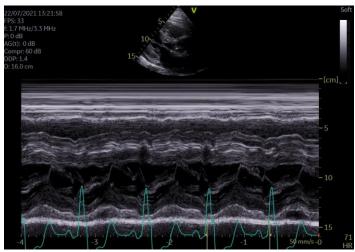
M-mode echocardiography showing SAM of the AML
